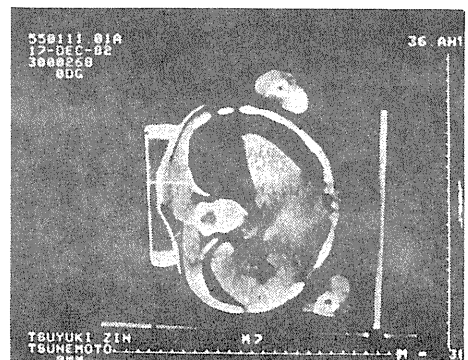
CT view of the case of leiomyosarcoma in Fig. 14.
